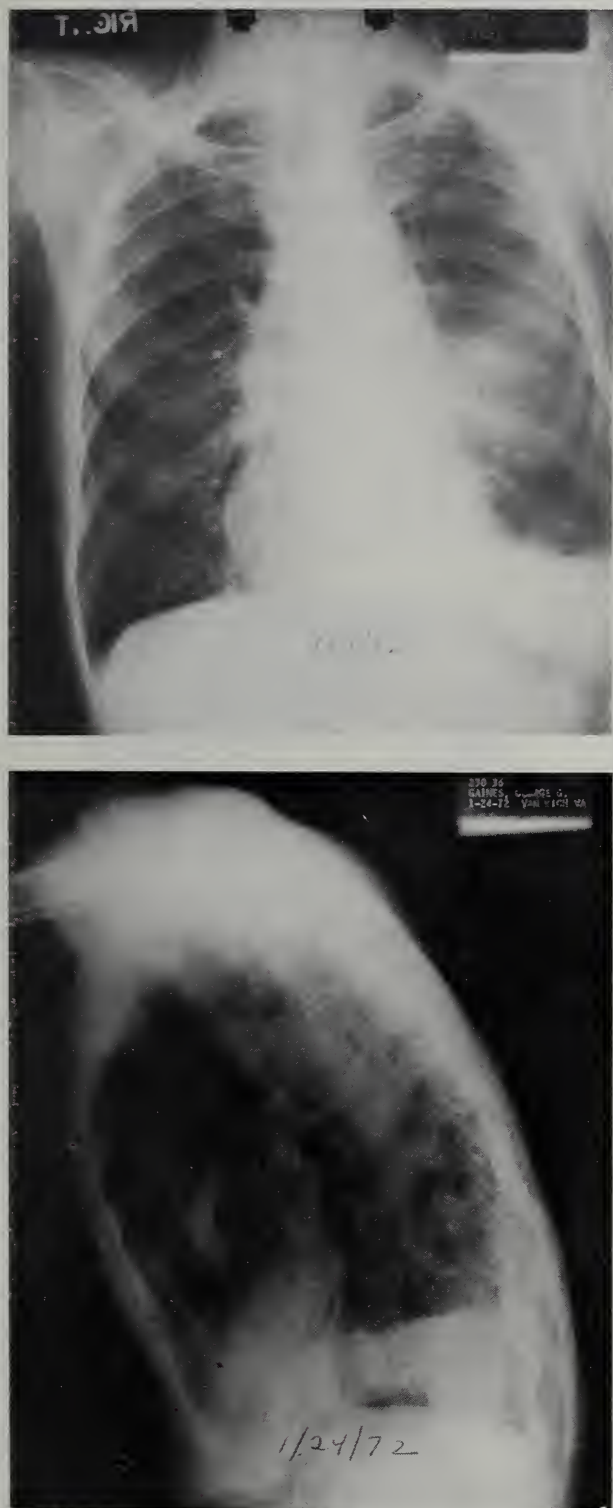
PA and lateral chest x-rays show clearing of density anteriorly and of pleural fluid.
